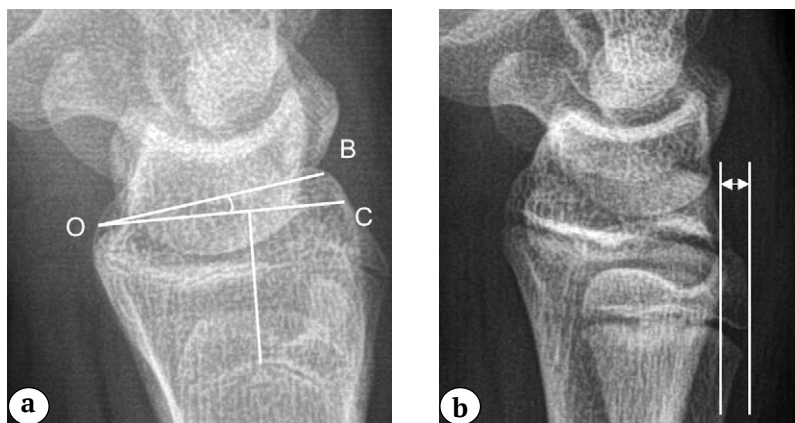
X-ray of the wrist joint in lateral projection: a – volar angle ($\angle BOC$) formed by line CO, perpendicular to the long axis of the radius, and line BO, connecting the two edges (dorsal and volar) of the articular surface of the radius; b – radioulnar distance between the dorsal contours of the epiphyses of the radius and ulna
